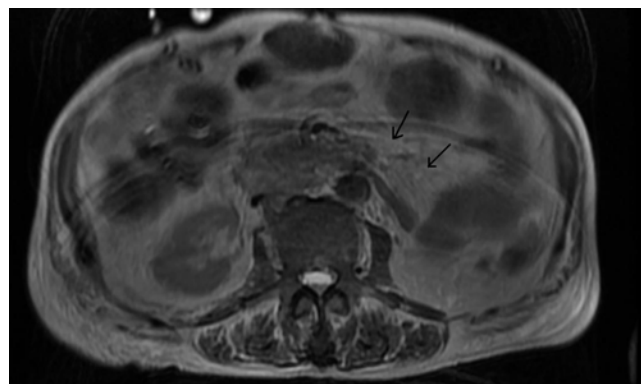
T2 weighted axial MR image shows full transection of the pancreas at the body with a fluid collection.
